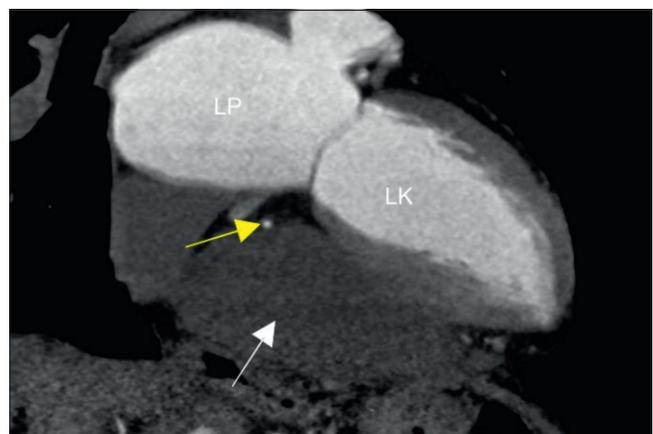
Computed tomography CT, multi-faceted reconstruction (MPR called. Multiplanar Reformation). White arrow – tumor change. Yellow arrow – right coronary artery modeled by a tumor
